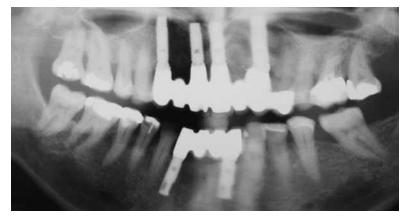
Radiograph after delivery of one piece porcelain to zirconia scew-retained restoration.
